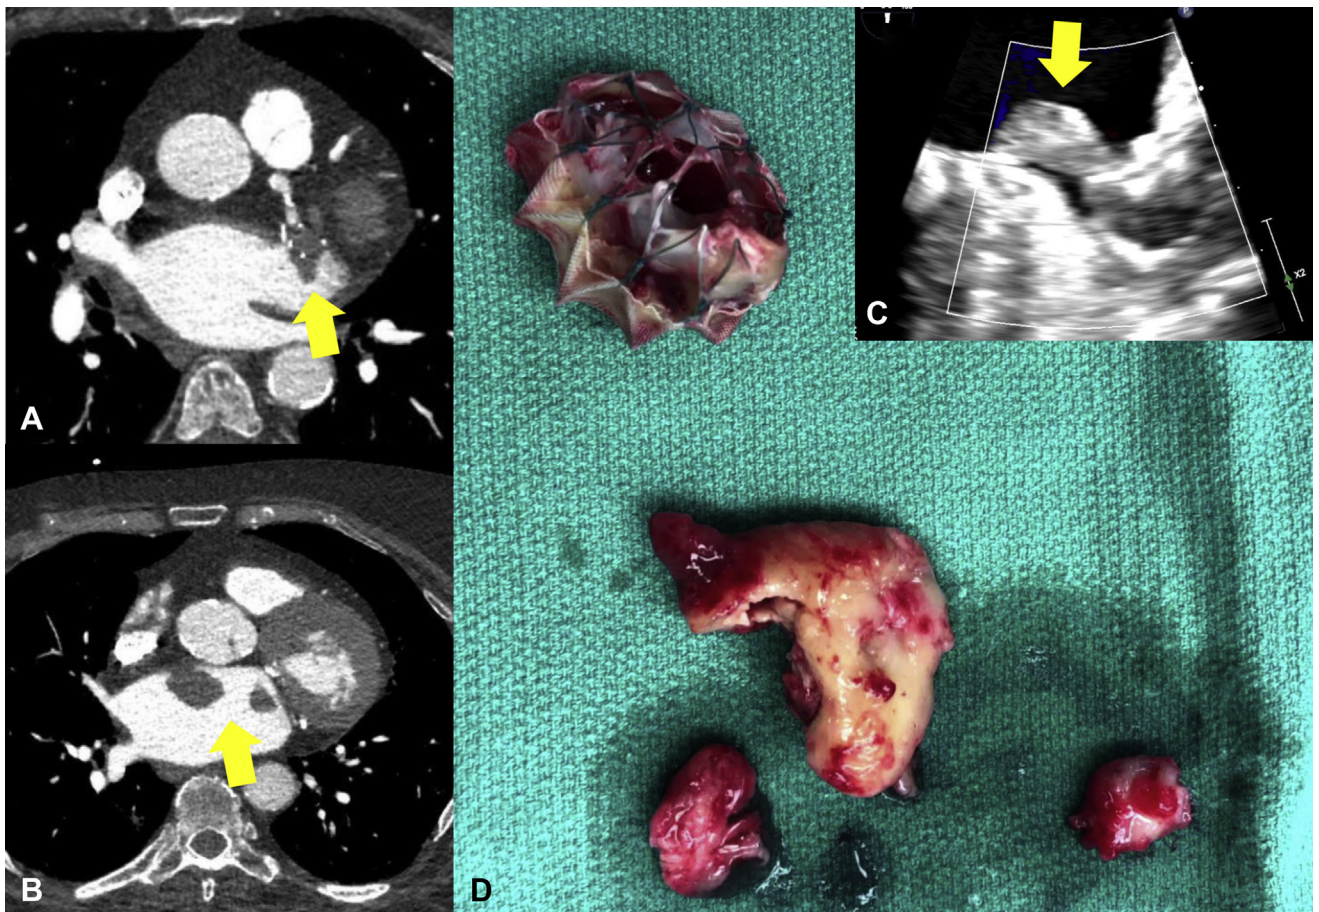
Explanted Watchman device with associated thrombi from a 77-year old woman with a history of severe aortic stenosis and atrial fibrillation status after failed ablation therapy who had a Watchman device placed in 2017 (case 1). Follow-up echocardiography and computed tomography scan (A and B) and transesophageal echocardiography (C) revealed the presence of multiple large thrombi in her left atrium that were associated with her device. She underwent an aortic valve replacement, biatrial Maze, and extraction of the left atrial thrombus and Watchman device (D), with closure of her left atrial appendage using a 45-mm AtriClip.
